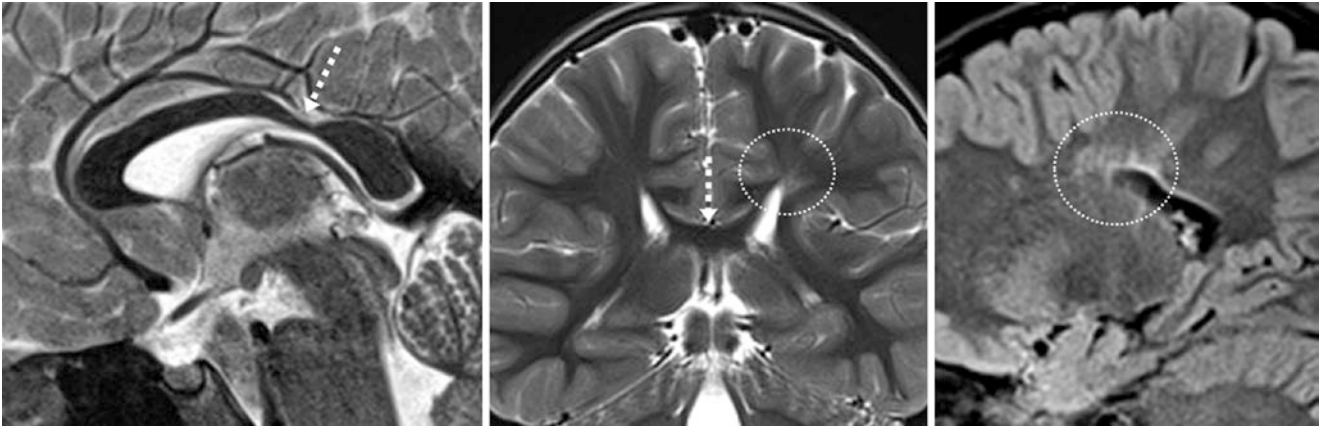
Comparison case of atrophy. An 8 year old with cerebral palsy had a 3T MRI that showed focal atrophy of the callosal isthmus (dashed arrows) on sagittal T2WI (left), with periventricular hyperintensity (dotted circles) on the left side on coronal T2WI (middle) and on sagittal FLAIR (right); ex vacuo dilatation of the left lateral ventricle was also observed
